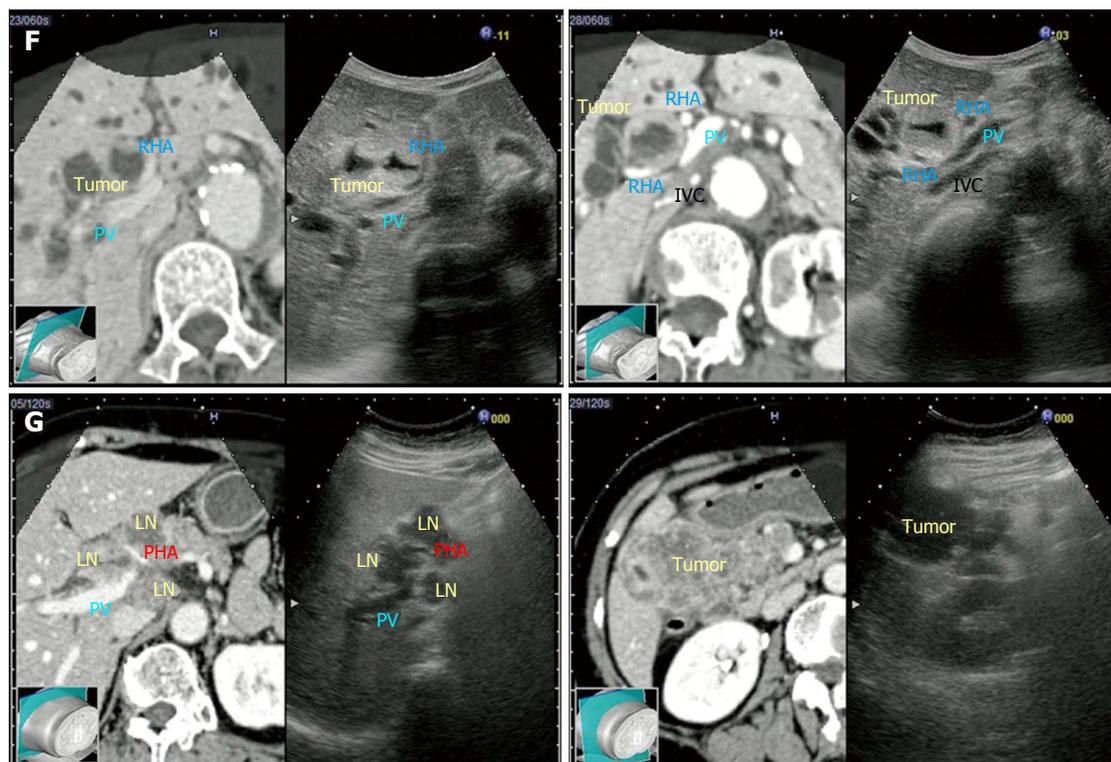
The resulting evaluation levels of the real-time virtual sonography images were 12 excellent (pancreatic cancer, bile duct cancer, cholecystolithiasis and cholangiocellular carcinoma) and 3 good (pancreatic cancer and gallbladder cancer). A: Pancreatic cancer (excellent case); the positional relationships among the tumor and vessels [superior mesenteric artery (SMA) and superior mesenteric vein, (SMV)] were well evaluated; B: Pancreatic cancer (excellent case); the positional relationships among the tumor, vessels [portal vein (PV)], common bile dilatation (CBD), and main pancreatic duct (MPD) were well evaluated; C: Bile duct cancer (excellent case); the positional relationships among the tumor and vessels (SMA, SMV and PV) were well evaluated; D: Bile duct cancer (excellent case); the positional relationship between the tumor and CBD was well evaluated; E: Bile duct cancer (excellent case); the positional relationships among the tumor and vessels [proper hepatic artery (PHA), right hepatic artery (RHA), PV] were well evaluated; F: Bile duct cancer (excellent case); the positional relationships among the tumor and vessels [RHA, PV and inferior vena cava (IVC)] were well evaluated; G: Gallbladder cancer (good case); there was a gap in the positional relationships among the tumor and vessels.
